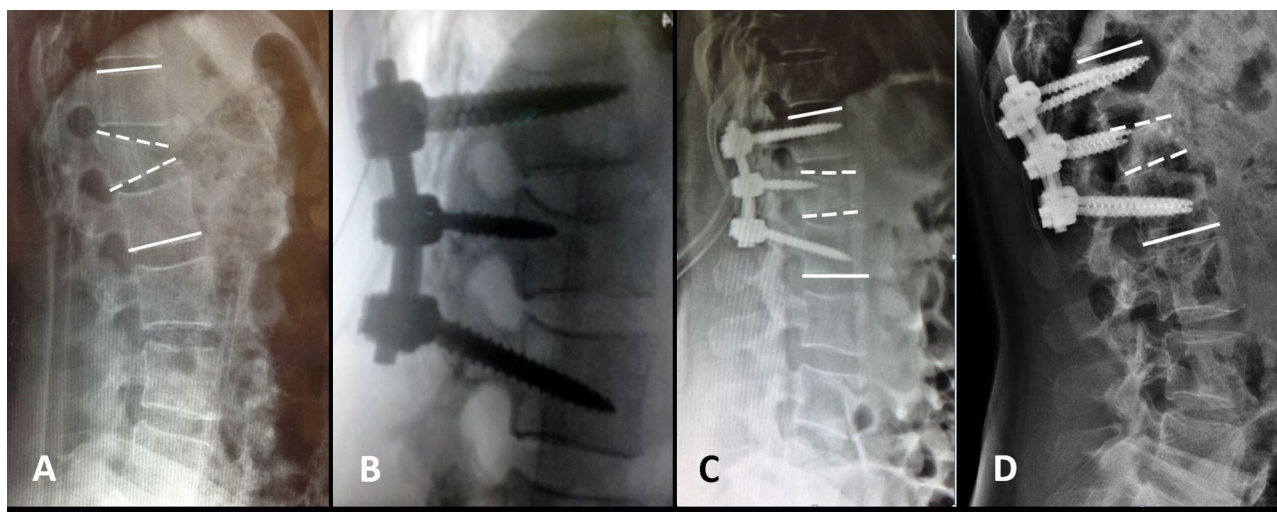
A) Preoperative lateral X-ray showing an AO-type B2 fracture of L1. Straight lines represent the segmental kyphosis. Dashed lines depict the wedge angle. B) Intraoperative fluoroscopy showing fracture reduction and fixation with short segment stabilisation and bilateral IS. C) Postoperative X-rays show the correction of segmental kyphosis and wedge angle. D) Lateral X-ray at 1-year follow-up showing the bone healing without major loss of correction.
